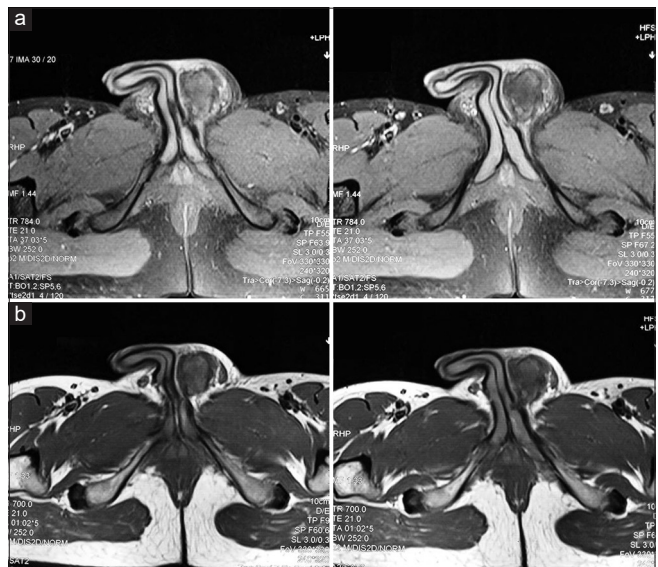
Magnetic resonance imaging images of a patient presenting 3 weeks after fall over an erect penis 1a: Non contrast T2 fat saturated and 1b: T1W image showing heterogeneous hyperintensity suggestive of hematoma. The defect in the left corpora is also seen
